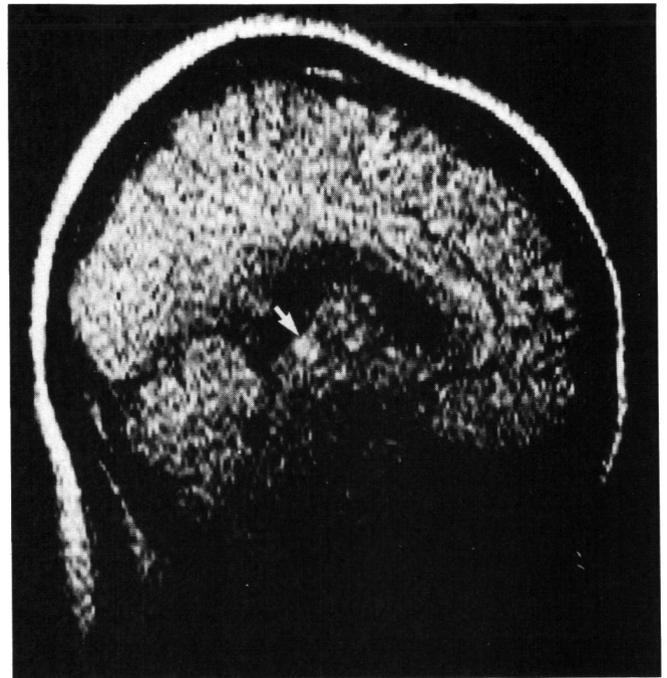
Midsagittal MRI using a single slice spin echo (SE) technique (TE = 60, TR = 1000) 2 weeks after the acute onset of the dorsal midbrain syndrome. A discrete round area of increased signal intensity (prolonged T₂) can be seen in the dorsal midbrain (arrow). An inversion-recovery (IR) image (not shown) of the same slice showed signal void in the same location but this could not be reliably distinguished from the low signal of the adjacent quadrigeminal cistern.
